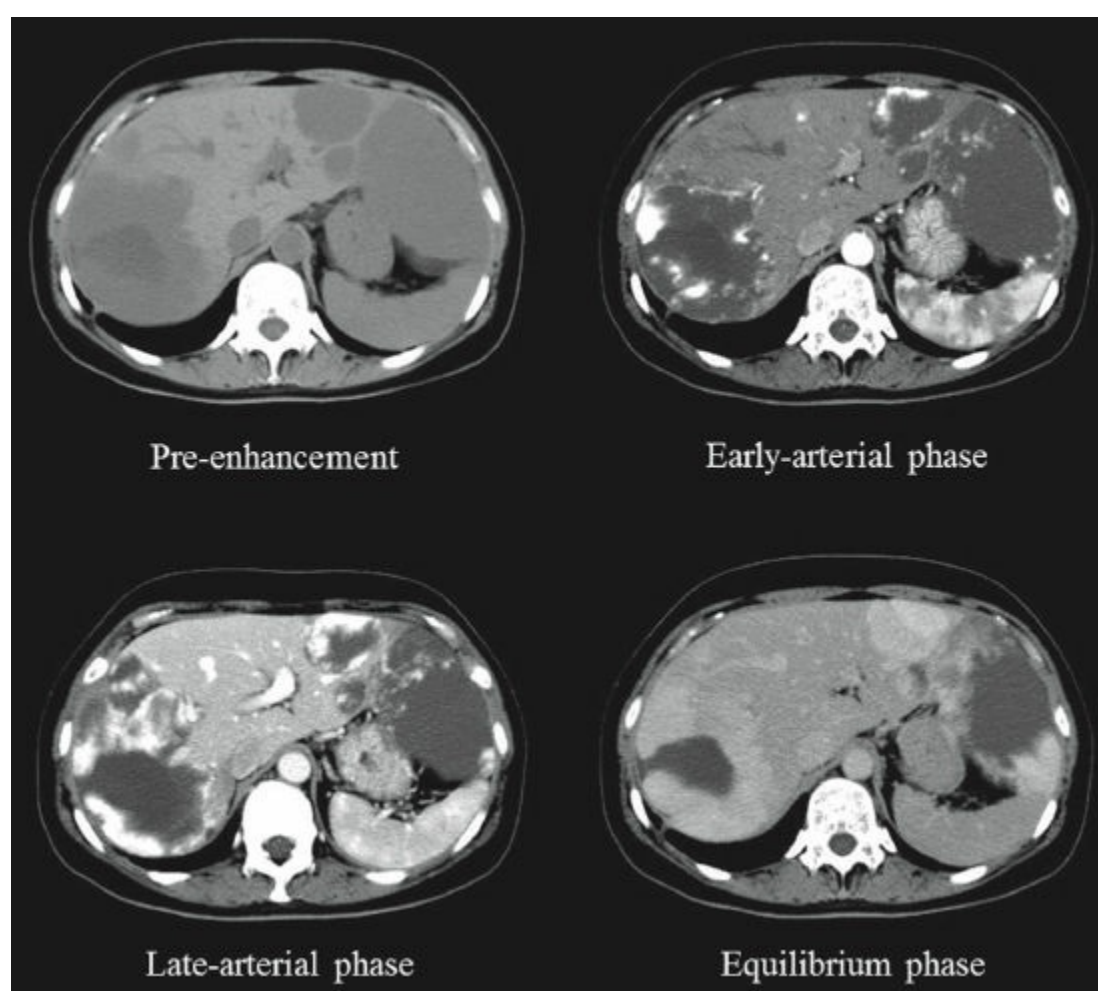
Nodular enhancement typically observed in hemangioma in dynamic CT. The mass is gradually enhanced from the peripheral part to the central part of the lesion.
